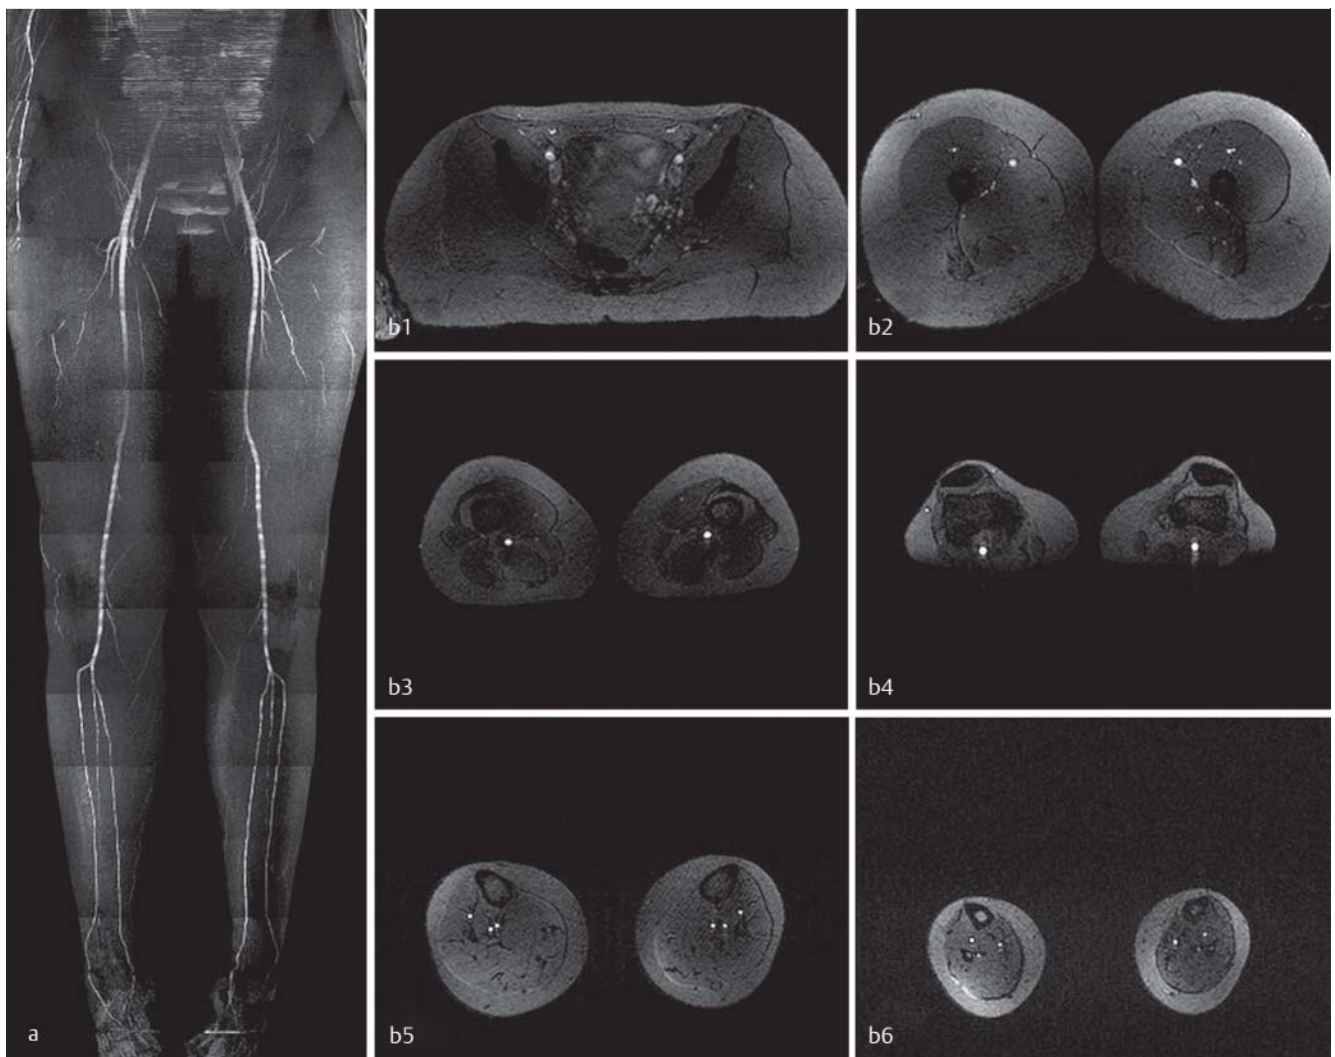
a shows 7 Tesla maximum intensity projection image of non-enhanced T1-weighted 2D FLASH MRI, covering the arterial vasculature from pelvis to feet b1–6. Due to effective saturation pulses the signal of surrounding background and venous vasculature could be successfully suppressed [70] (Courtesy of Dr. A. Fischer, Department of Diagnostic and Interventional Radiology and Neuroradiology, University Hospital Essen, Germany).
